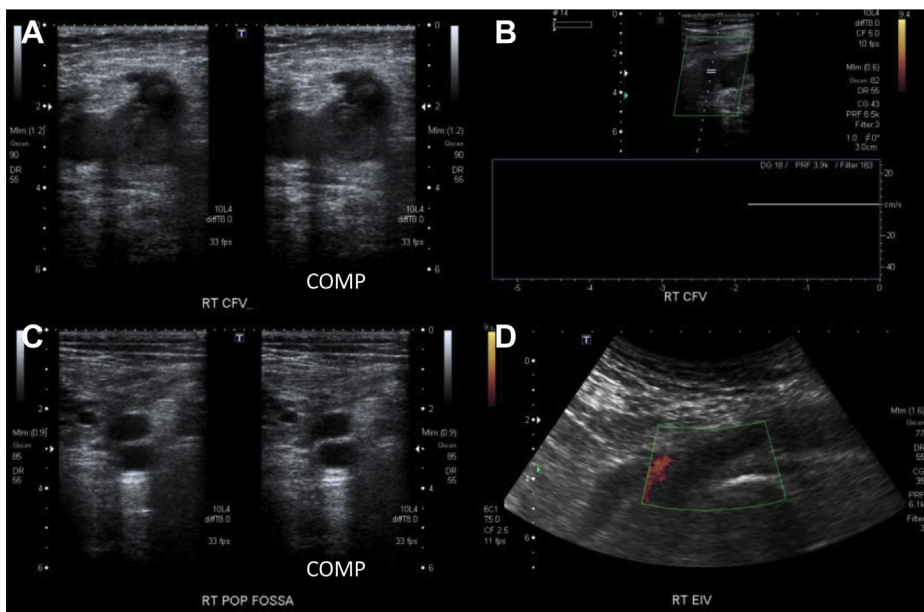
Duplex venous ultrasound images on presentation to the emergency department. A, Occlusive thrombus is noted in the right common femoral vein with intraluminal echoes and noncompressibility of the right common femoral vein. B, Intraluminal echoes with no venous waveform or filling of the right common femoral vein on spectral Doppler compatible with occlusive thrombus. C, Anechoic, noncompressible right popliteal vein compatible with acute thrombus. D, Occlusive thrombus in the right external iliac vein.
